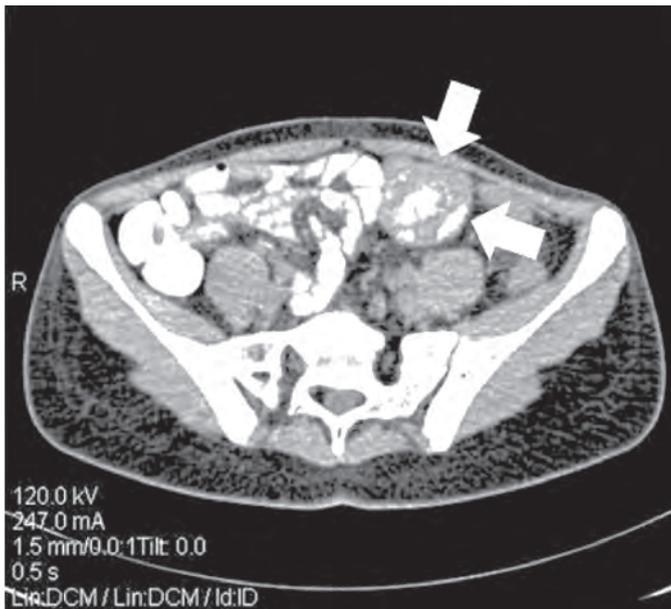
Case 8: An axial abdominal CT scan with intraluminal contrast reveals a spherical mass in the left iliac area with well-defined contours, high soft tissue density, and multiple mottled calcifications (arrows).
